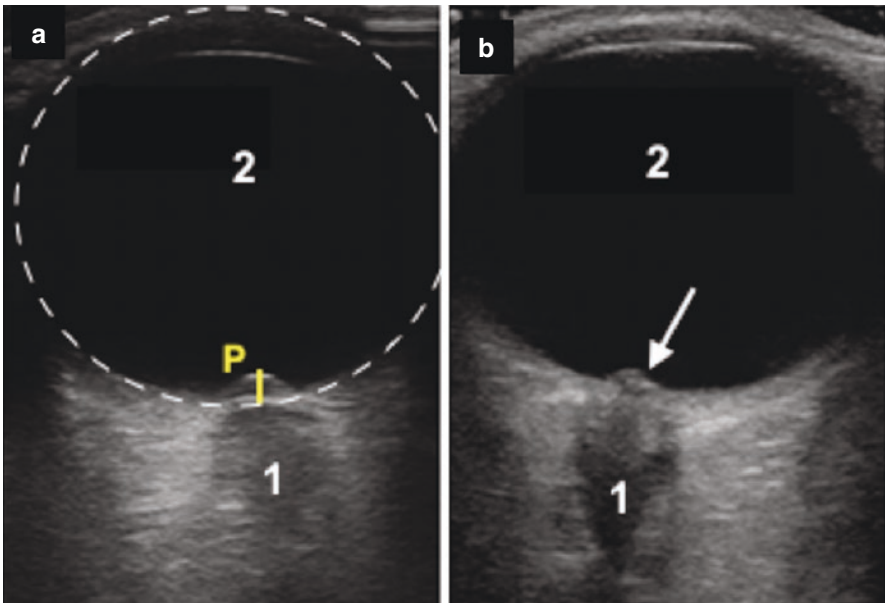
OCCS: B-Mode Ultrasound of the papilla through Axial (transverse) plane: (a) (1) Optic nerve, (2) Bulbus (eyeball), (Dotted line) circle to define the papilla, (P) Papilla prominence (papilledema) and (yellow line) Distance between the circle and papilla prominence; (b) (1) Optic nerve, (2) Bulbus (eyeball) and (arrow) Papilla prominence (papilledema)
